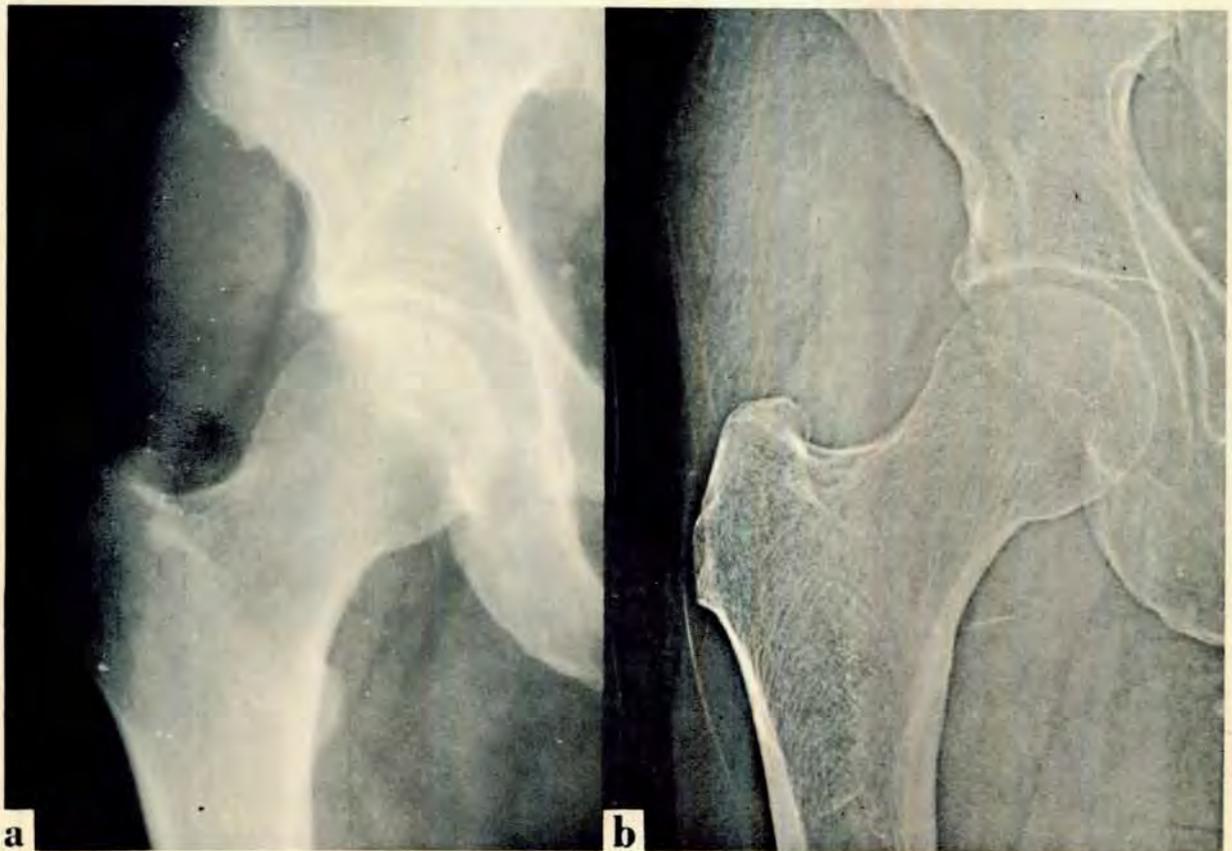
Same diver as in Fig. 1. Comparison of (a) frontal roentgenogram of R hip with (b) xeroradiogram of R hip.
